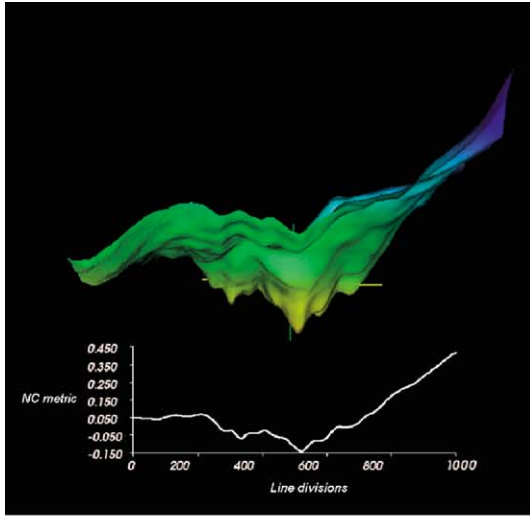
The mutual information metric (a) and the narrow band metric (b) as a function of relative displacement in the  $xy$  plane. Two identical magnetic resonance images (from Fig. 2a) were used as the input fixed and floating images. The insert in each panel shows the corresponding metric when the displacement is confined to the  $x$ -direction. The mutual information metric is seen to be very “noisy” and multiple maxima exist. The narrow band metric, on the other hand, is much smoother and has a single minimum.
